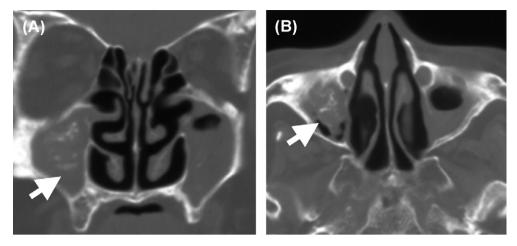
CT images of the patient at the first visit to our clinic in May 2000. Mucosal thickening and multiple mottled calcifications without bone destruction are seen in the right maxillary sinus (arrows), diagnostic of non-invasive fungal maxillary sinusitis.
